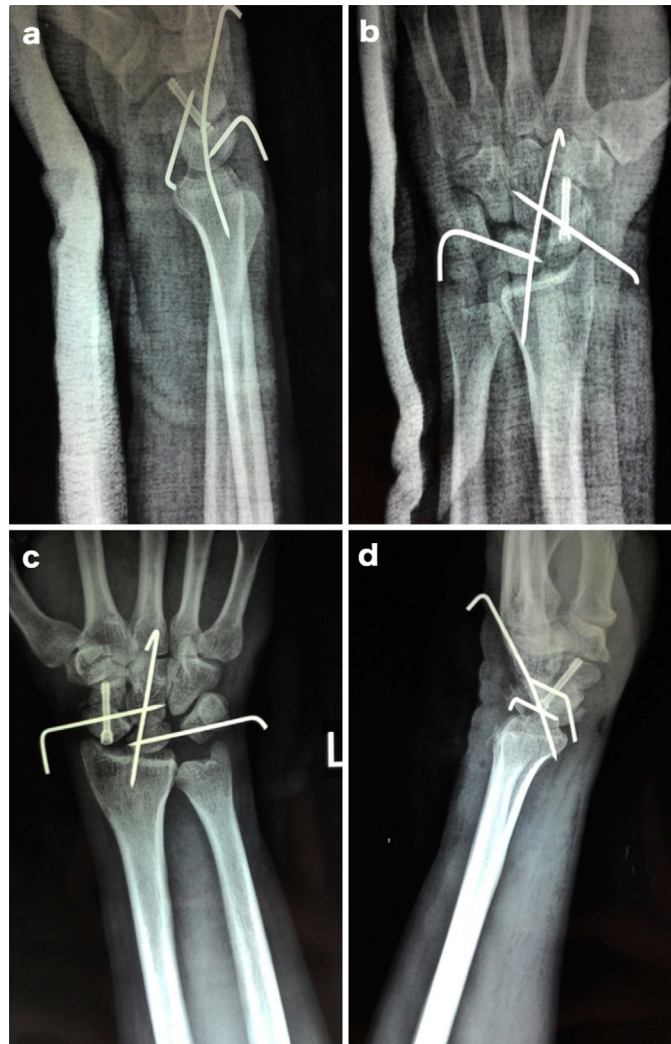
Postoperative X-rays showing fixation. Right side (a and b) and left side (c and d).
